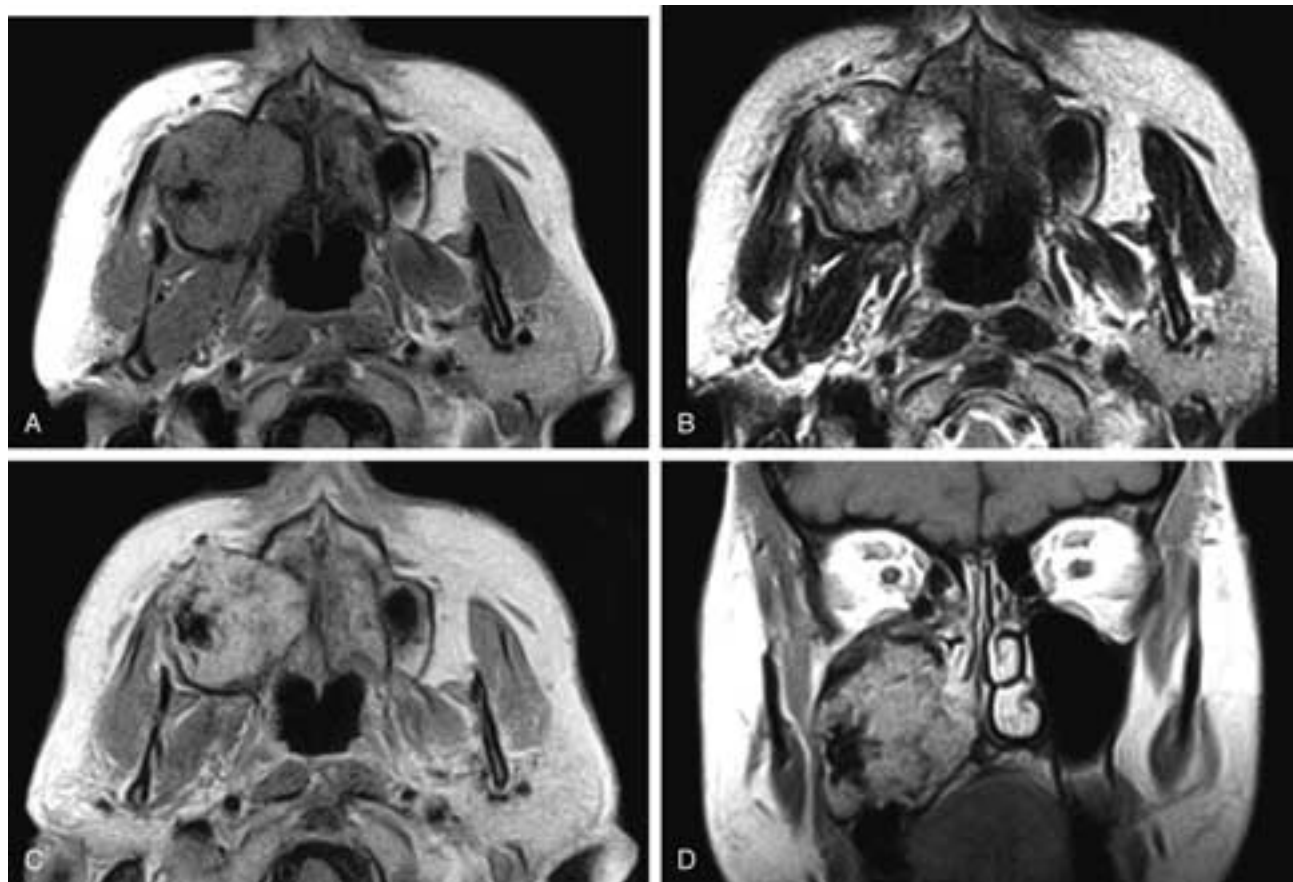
Axial T1-weighted (A), T2-weighted (B), and axial (C) and coronal (D) T1-weighted, contrast-enhanced MR images show a soft tissue mass in the right maxillary sinus with a low T1-weighted signal intensity and a nonhomogeneous T2-weighted signal intensity. The mass enhances slightly. There are areas of signal void within the lower lateral aspect of the mass on all sequences that were calcifications. This patient had a calcifying epithelial odontogenic tumor.
